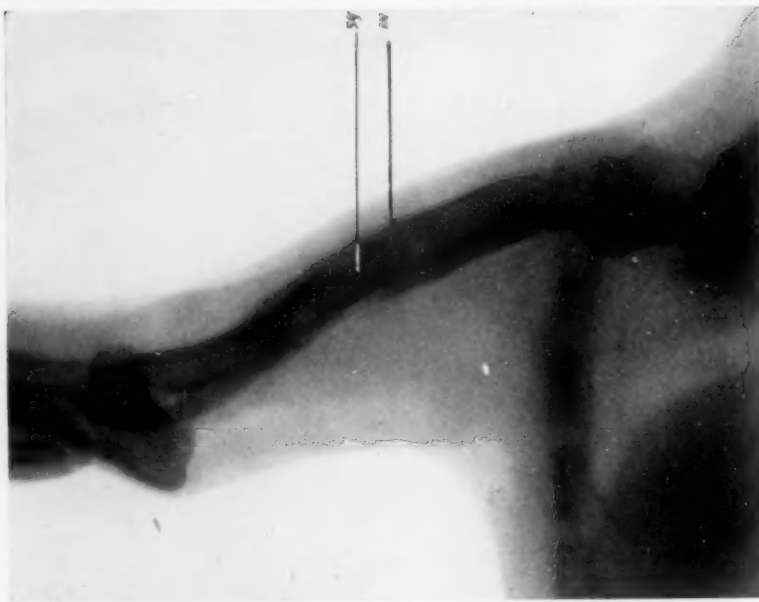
(Path. No. 5942).—X-ray December 1, 1919. Sequestrum and involucrum, but less marked than previous. *In*, involucrum; *Sg*, sequestrum.
